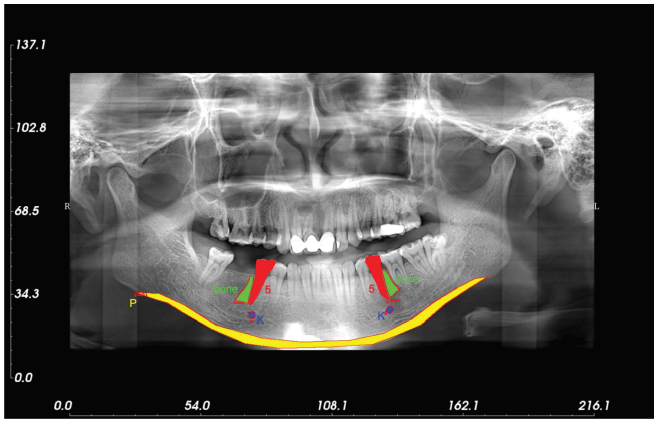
Annotated dental panoramic radiograph with color-coded masks
